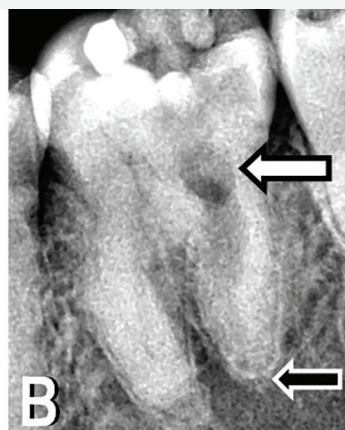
Preoperative radiograph – a large IRR lesion extended from the pulp chamber (white arrow) to the middle third of the distal canal. The cortical bone and the periapical tissues are within normal limits (black arrow)
